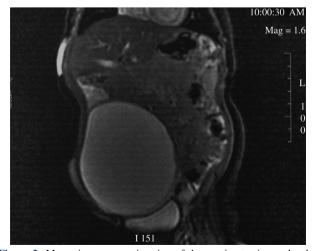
Magnetic resonance imaging of the ovarian torsion and voluminous cystic mass.
